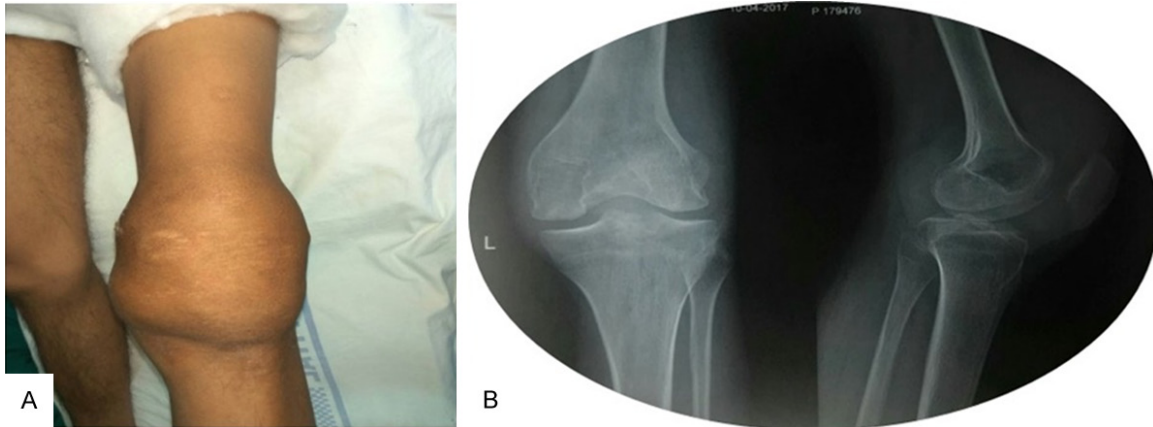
Showing diffuse swelling around the left knee (A) and an X-ray of knee anteroposterior and lateral view suggesting prominent soft tissue shadow, widening of intercondylar notch and areas of cortical scalloping suggesting chronic compressing changes (B).
